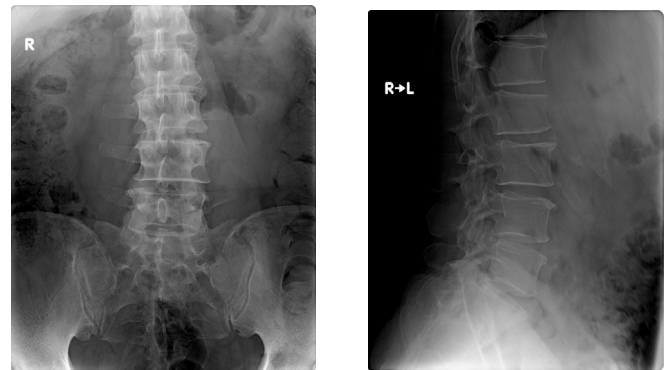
x-ray findings of the lumbar region (spondylopathy)
